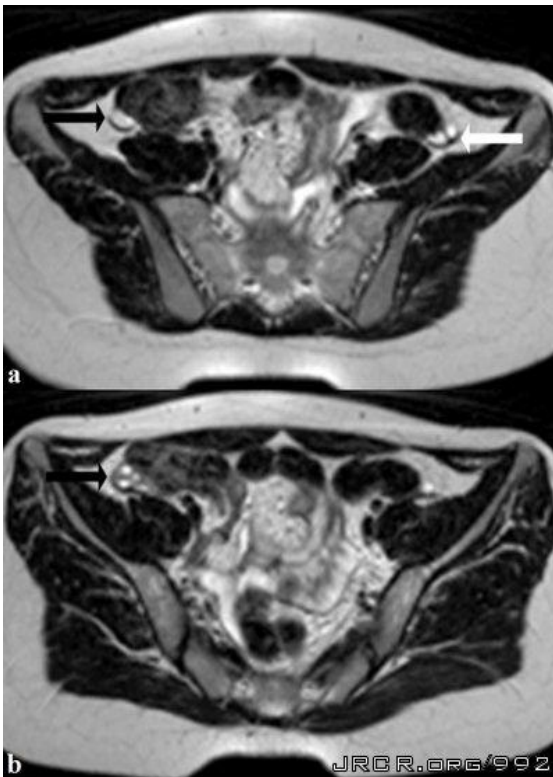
MRI shows absent uterus and presence of ovaries
